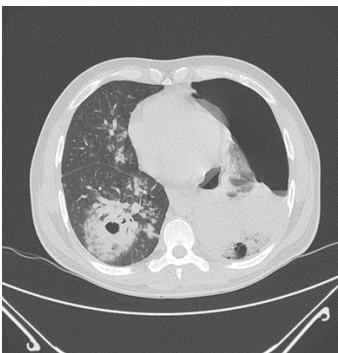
HRCT chest – Lung window.
